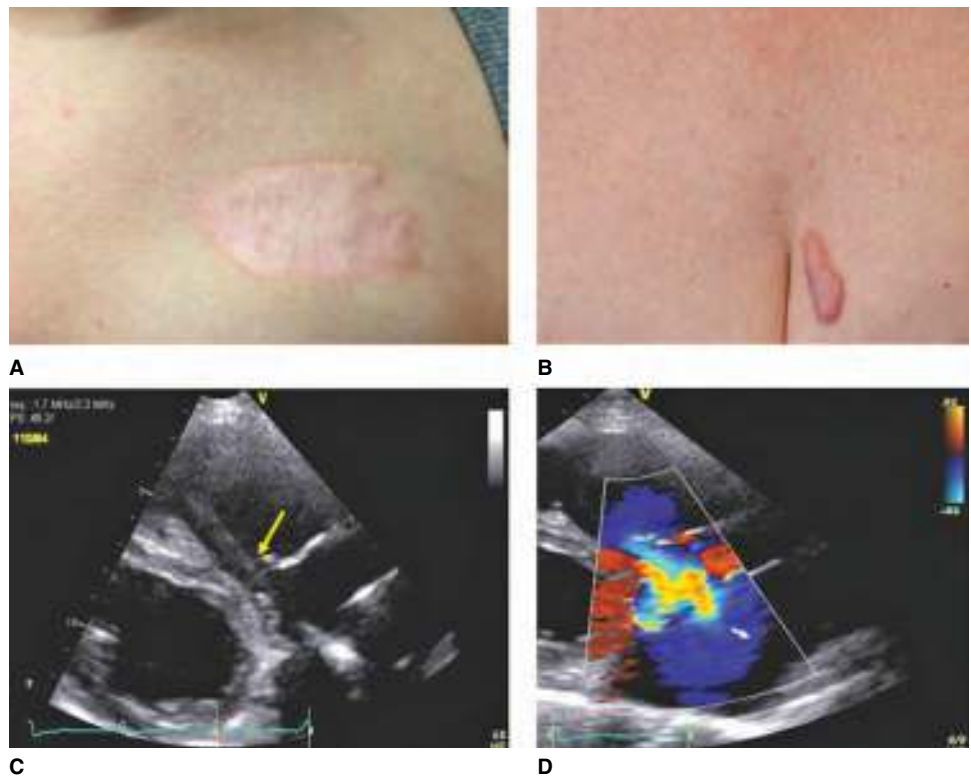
Intermediate-term complications associated with pacemaker implantation. A. Hypertrophic scar. B. Keloid formation. C. M-mode echocardiographic image of the RV lead through the tricuspid valve (arrow). D. Doppler image of figure C demonstrating severe tricuspid regurgitation. (Used with permission from reference 7.)
